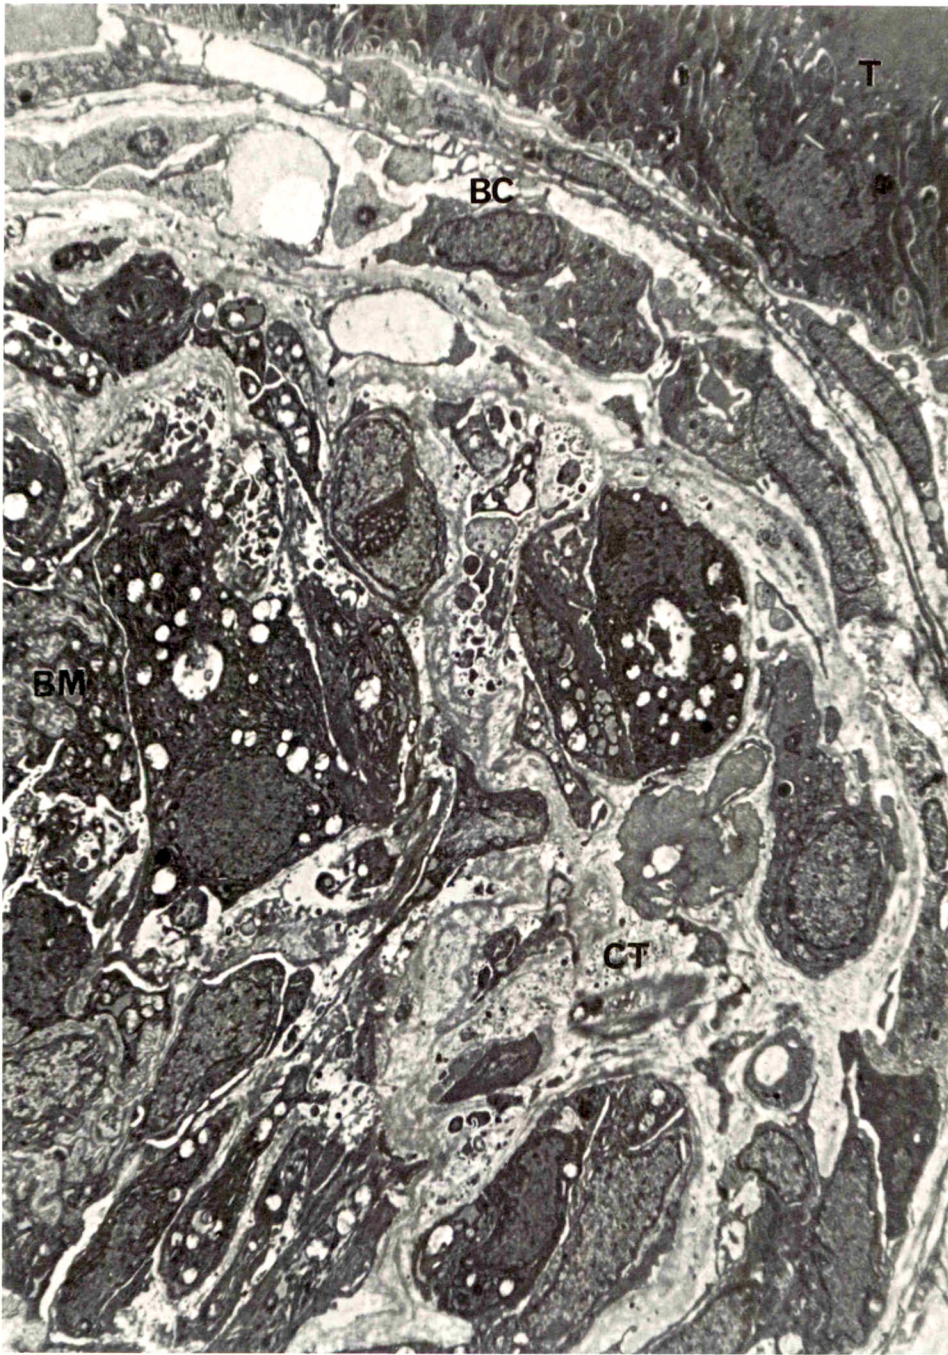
Nephrotoxic nephritis. Glomerulus 18 days after injecting anti-kidney antibody. The capsular space is filled with inflammatory cells, fibroblasts and epithelial cells with strands of collagen and fibrin interspersed (A crescent, $\times 2800$). *T* = Tubular cell; *BC* = Bowman's capsule; *CT* = Connective Tissue; *BM* = Wrinkled collapsed capillary basement membrane.
